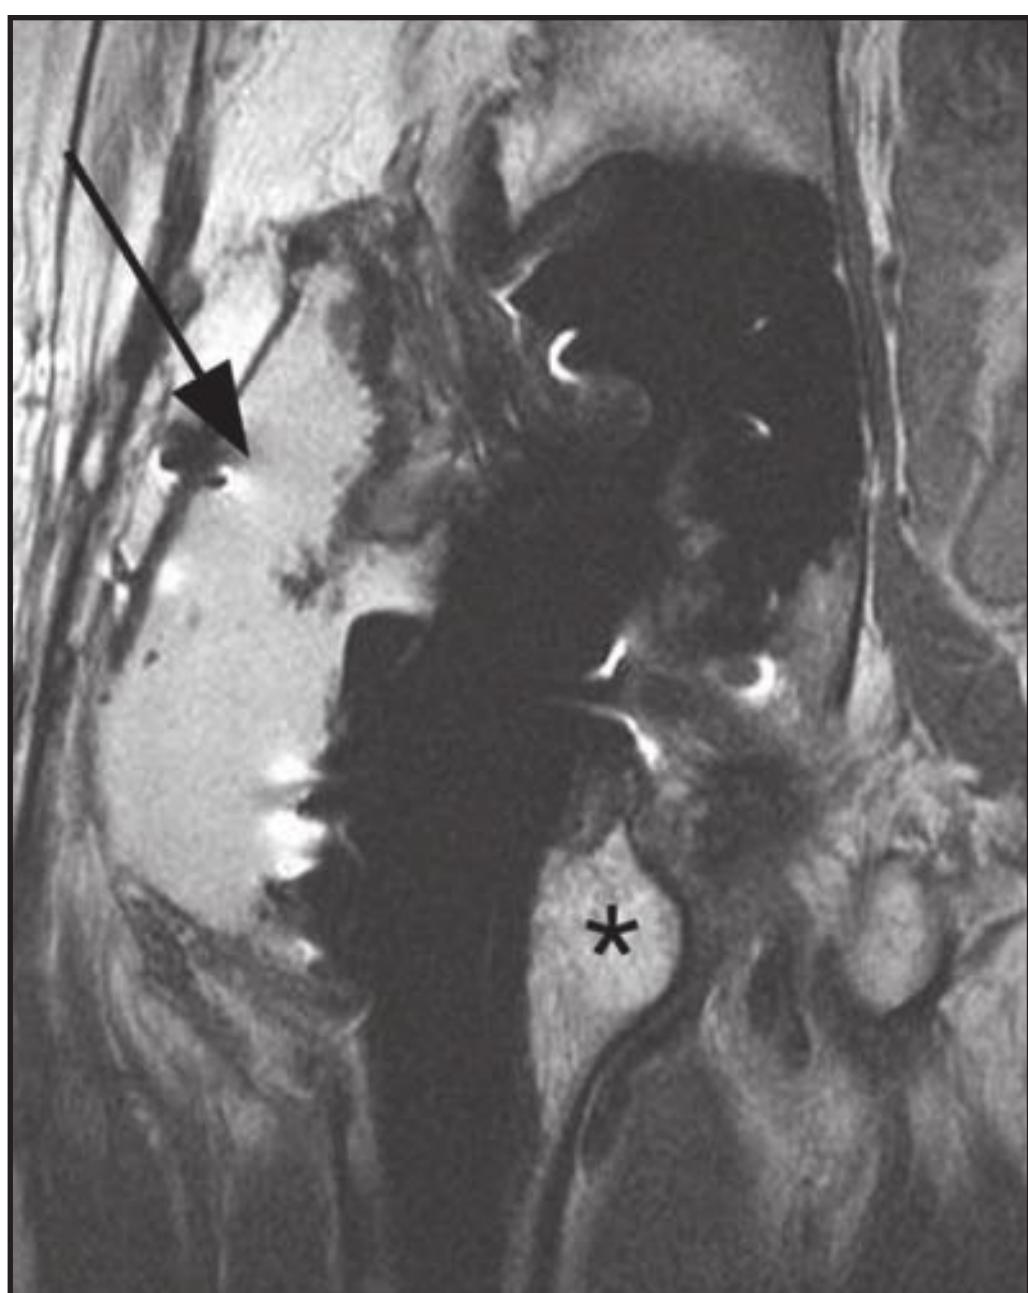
MRI demonstrating trochanteric bursitis after THA
